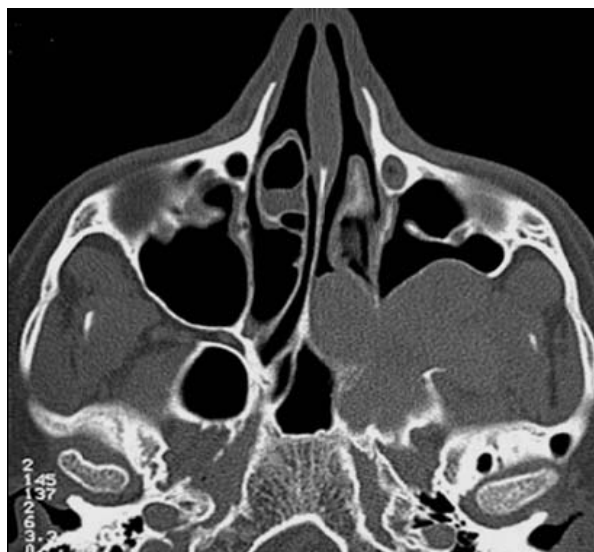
Axial CT; The posterior wall of the maxillary sinus has been bowed anteriorly (arrowed)
